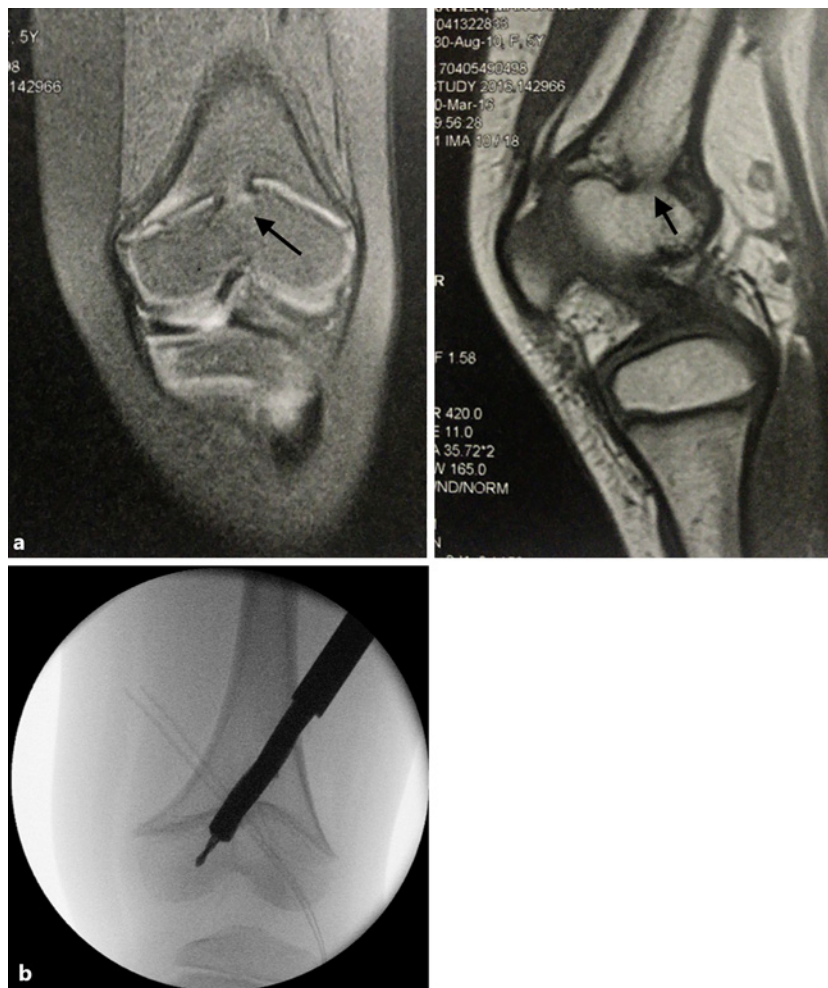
PPB. a Preoperative image on MRI showing the bar occupies <20% of the DFP (black arrows indicating the central physal bar). b Intraoperative fluoroscopic imaging of a high-speed burr. PPB, partial physal bar; DFP, distal femoral physis.
